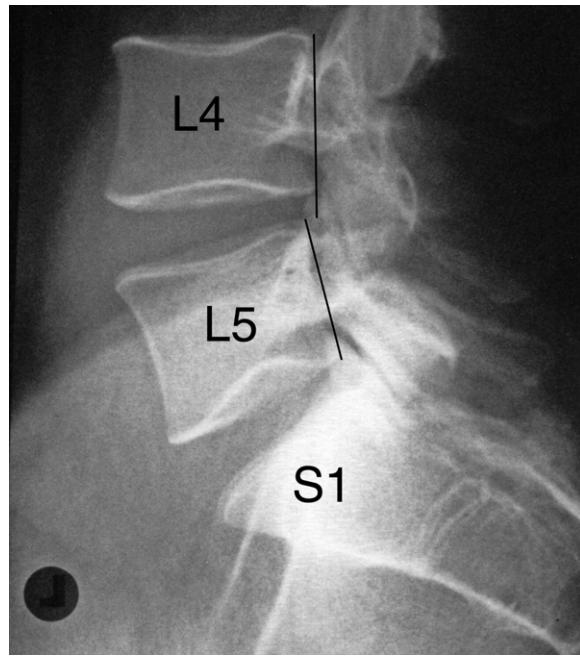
Lumbosacral spine lateral plain X-ray image that shows some retrolisthesis of the L4 vertebral body on the L5 vertebral body as indicated by the black lines drawn along the posterior margin of the L4 and L5 vertebral bodies, respectively. No vertebral body margin lipping is present. L4 = 4th lumbar vertebra; L5 = 5th lumbar vertebra; S1 = first sacral segment.
